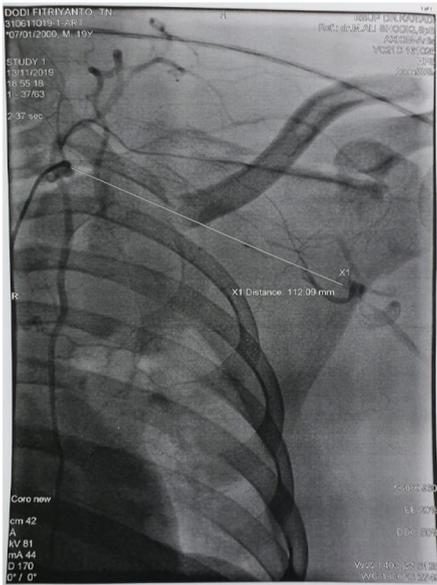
An X-ray showed discontinuity of the left subclavian artery with medial punctum separated with distal punctum by 11cm with collateral vascular appearance.
